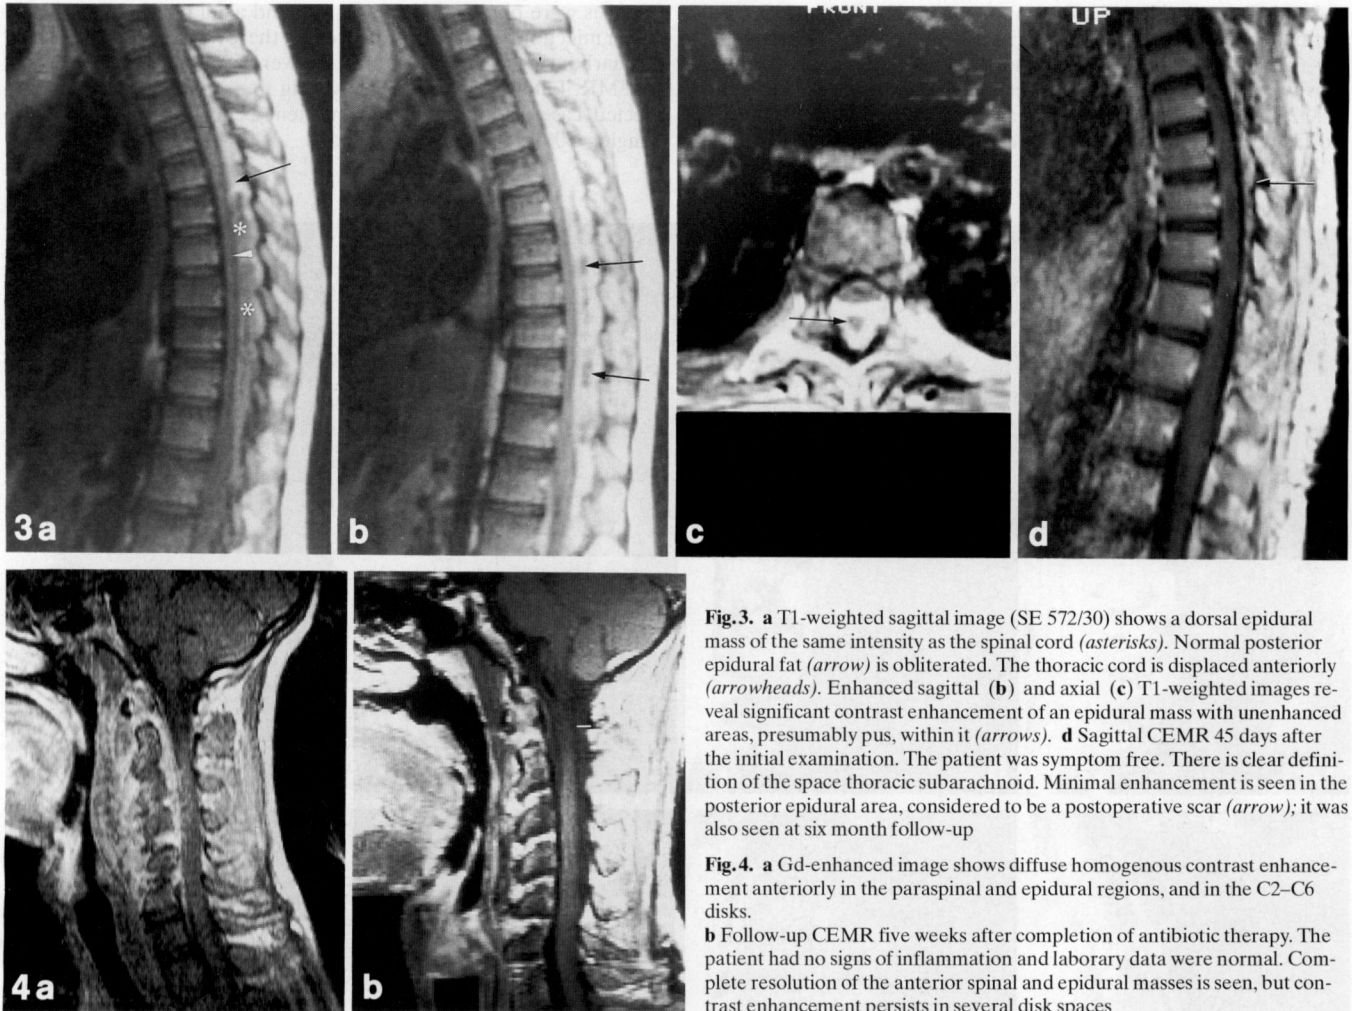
a T1-weighted sagittal image (SE 572/30) shows a dorsal epidural mass of the same intensity as the spinal cord (asterisks). Normal posterior epidural fat (arrow) is obliterated. The thoracic cord is displaced anteriorly (arrowheads). Enhanced sagittal (b) and axial (c) T1-weighted images reveal significant contrast enhancement of an epidural mass with unenhanced areas, presumably pus, within it (arrows). d Sagittal CEMR 45 days after the initial examination. The patient was symptom free. There is clear definition of the space thoracic subarachnoid. Minimal enhancement is seen in the posterior epidural area, considered to be a postoperative scar (arrow); it was also seen at six month follow-up
